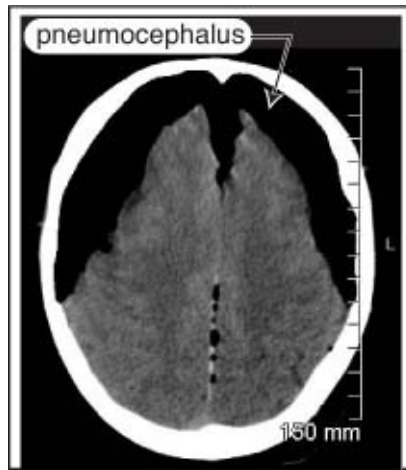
Mt. Fuji sign with bilateral pneumocephalus. Axial noncontrast CT scan
